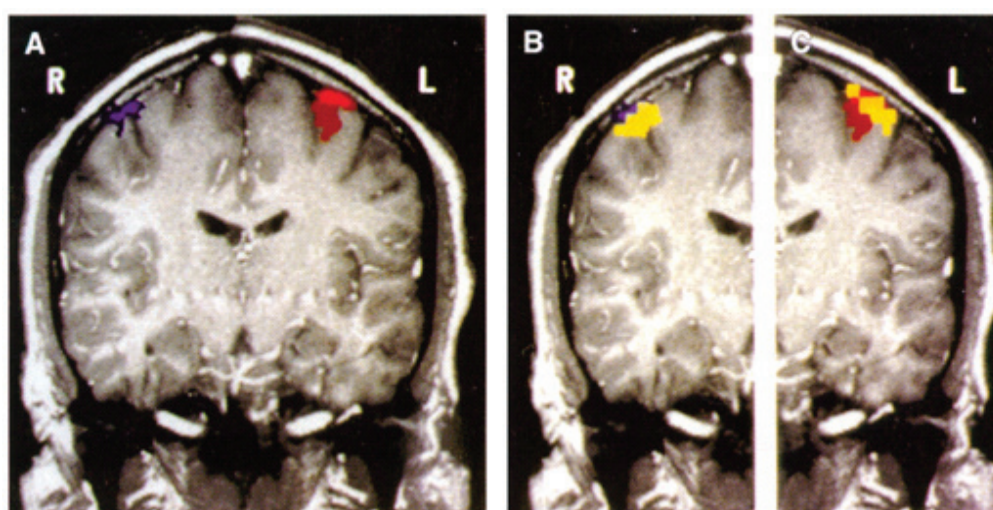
Comparison of optical and functional magnetic resonance images of motor cortex activation.
